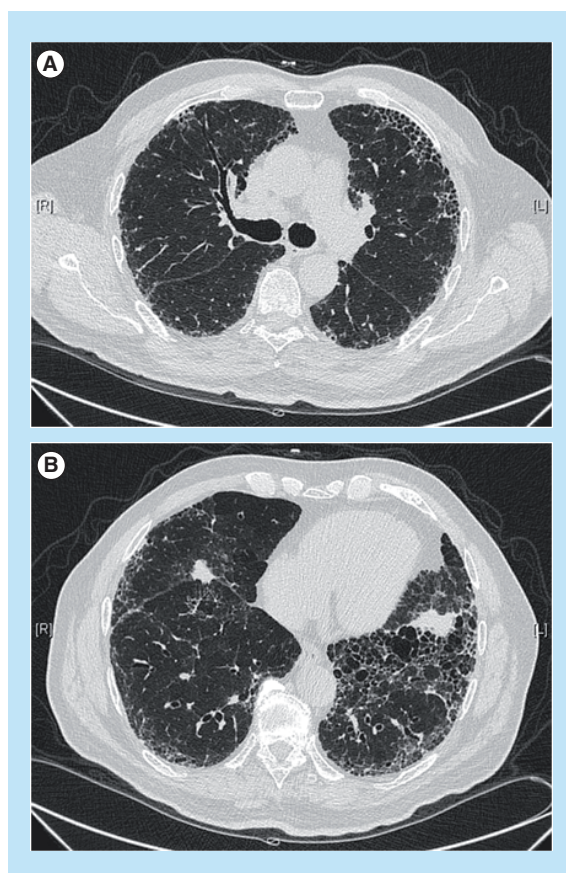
High resolution computed tomography scan of the chest of a patient with idiopathic pulmonary fibrosis, demonstrating a typical pattern of usual interstitial pneumonia with reticulation, subpleural and basal predominance of lesions, traction bronchiectasis and honeycombing. (A) Level of the carina; (B) level of the lower lobes.
